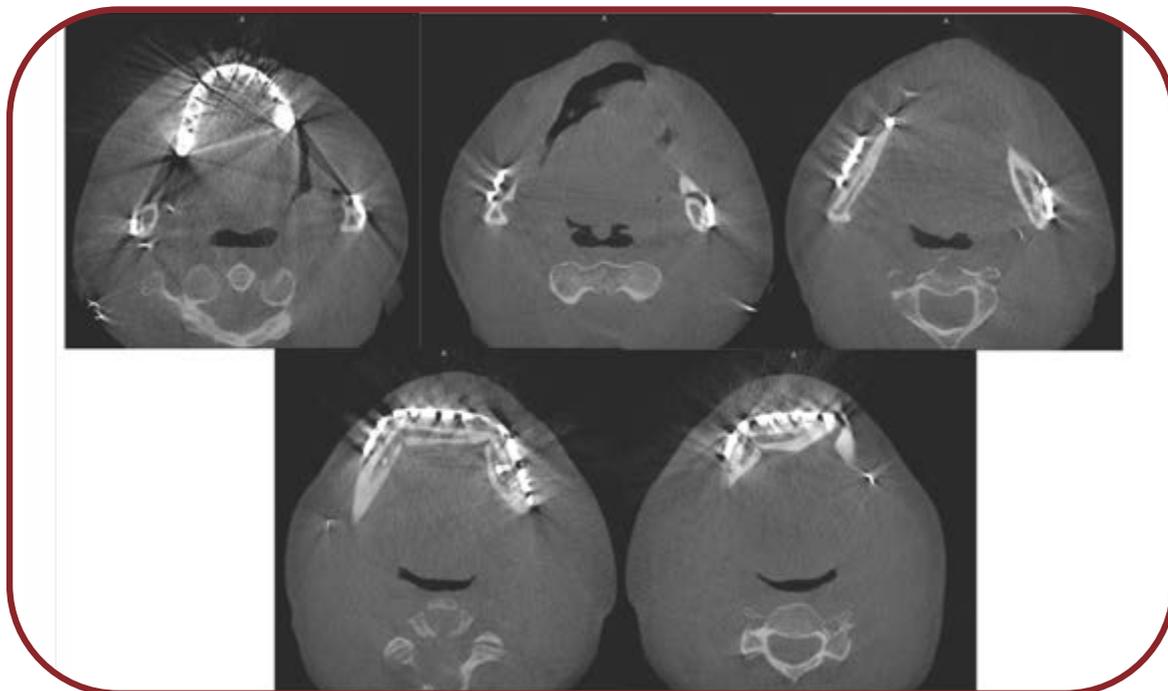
CT images at one month postoperatively
